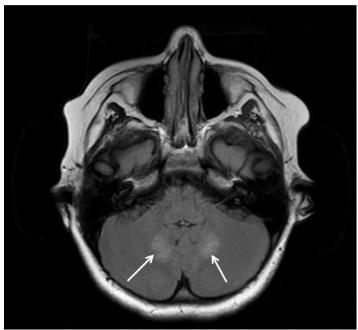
and fluid-attenuation inversion recovery sequence magnetic resonance imaging of brain showing symmetric hyperintense dentate nuclei lesions that are characteristic of metronidazole-induced encephalopathy.
